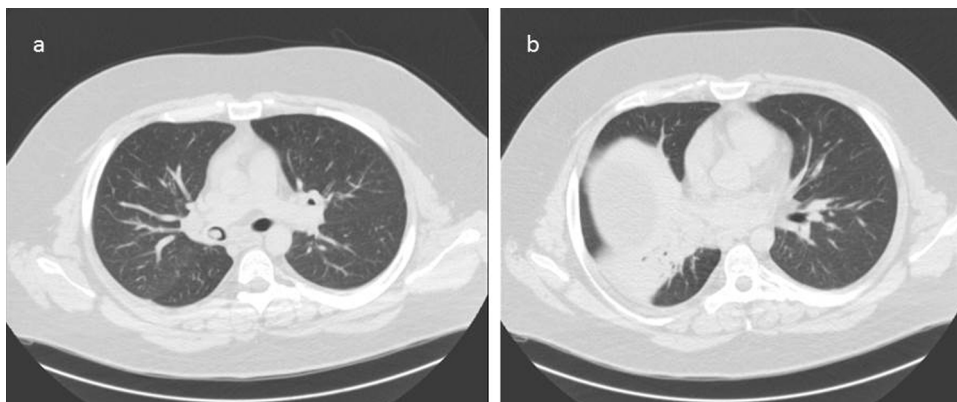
Computed tomography: (a) presence of a solid mass in the bronchus intermedius; (b) atelectasis of middle and lower right lobe.
